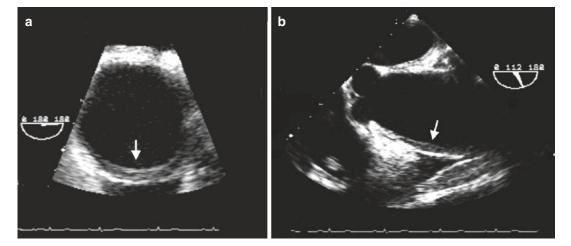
Short axis (a) and long axis (b) transesophageal echo images of intramural hematoma (arrow) in the ascending aorta. The luminal surface has a smooth surface, and the area of hematoma appears relatively hypoechoic
